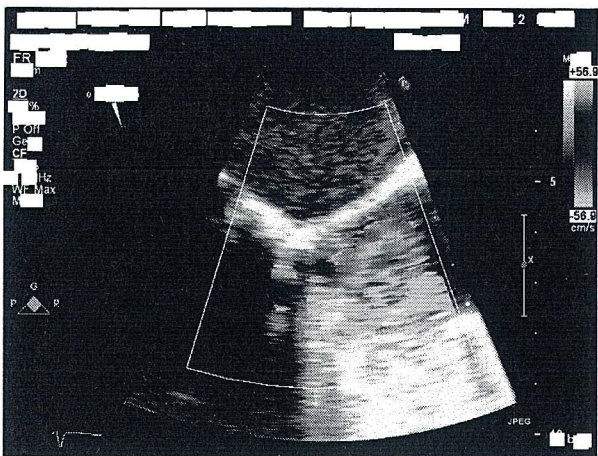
Standard cardiac ultrasound image produced by an alternative equipment.
